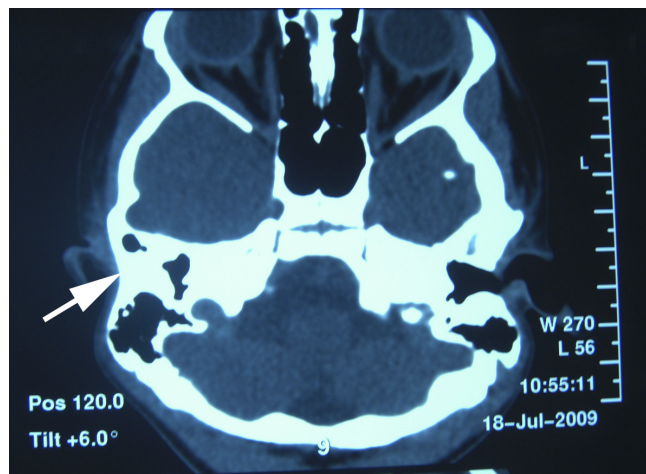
An axial CT shows right CAA with a well-developed middle ear space and pneumatized mastoid; the arrow points to the atretic plate.
